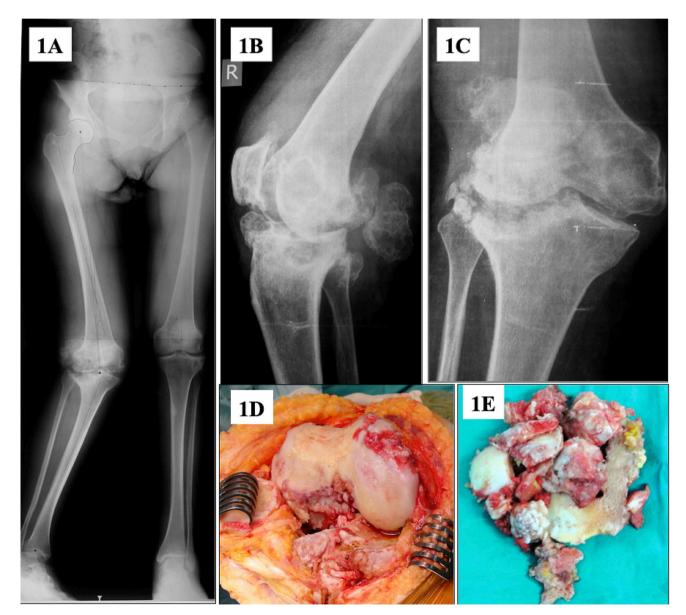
Severe valgus malalignment of the right knee, extensive bone destruction in the lateral compartment, large osteophytes and loose bodies can be seen in the AP standing full-length lower extremity (1A), standard lateral knee (1B) and AP knee radiographs (1C) of Case 2 at presentation. Advanced osteoarthritic changes (1D) and abundant amount of excised osteophytes and loose bodies (1E) were documented intraoperatively.
